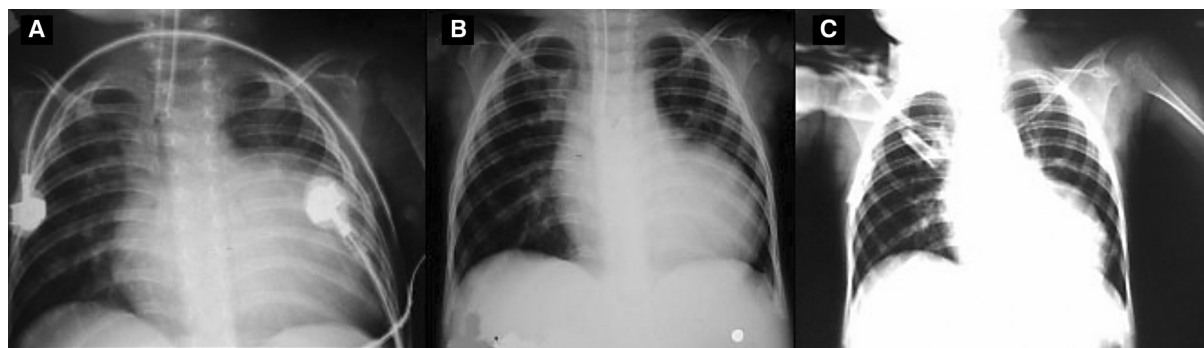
Radiographic progression of cardiomegaly: A) chest X ray before start of treatment, demonstrating a cardiothoracic index of 0.8 and pulmonary congestion with increased vascularity to the lung apices; B) chest X ray during fourth month of treatment, demonstrating reduction in cardiac area and regression of pulmonary congestion; C) chest X ray from 10th month of treatment, with a cardiothoracic index very close to normal
